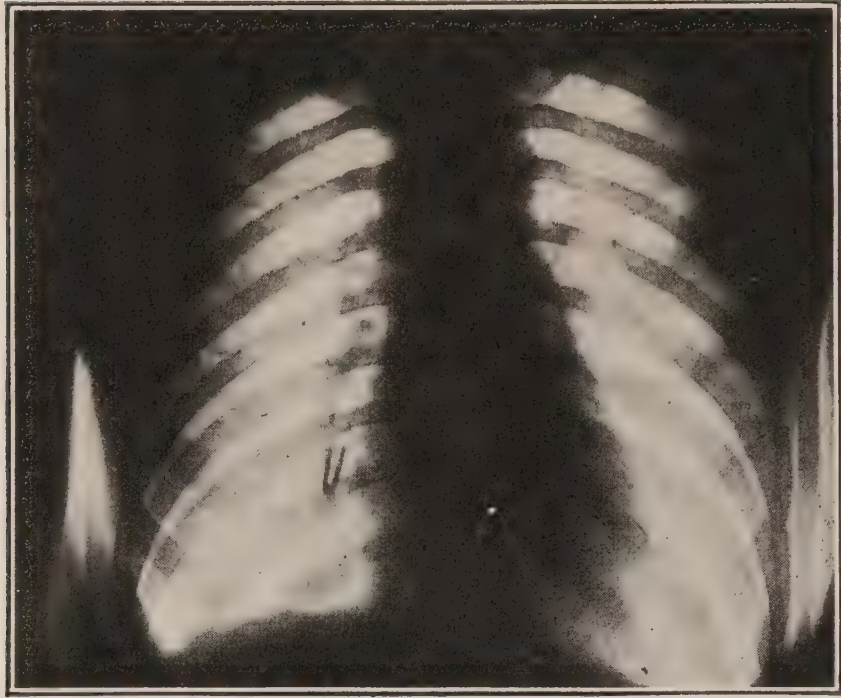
Radiographs, lateral and anteroposterior showing staple in a small posterior branch of the inferior lobe bronchus of a man aged 35 years. Staple was turned and removed bloodlessly through the mouth by bronchoscopy, under local anæsthesia. (*Author's case. Radiographs made by Johnston and Grier.*)
